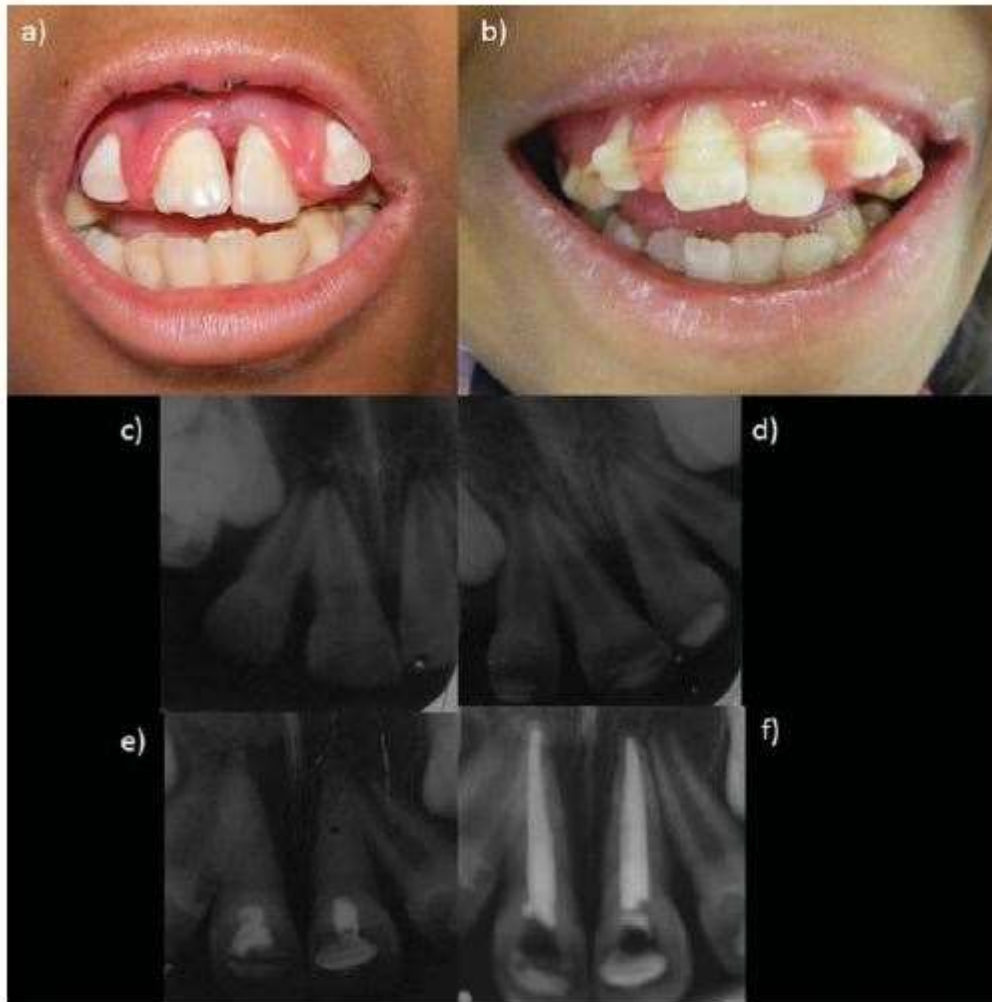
a) Traumatized upper central incisors at first visit; b) 4 days later, with better gingival condition, a flexible splint was anchored to the primary molar to allow periodontal healing of both traumatized incisors; c) periapical radiograph obtained at first visit; d) 3 weeks later, an initial process of external root resorption in both teeth was observed; e) introduction of calcium hydroxide paste to stimulate apexification of immature teeth; f) 5 months later, successful apical barrier formation was observed, with no signs of external resorption progression and final obturation of both incisors.
